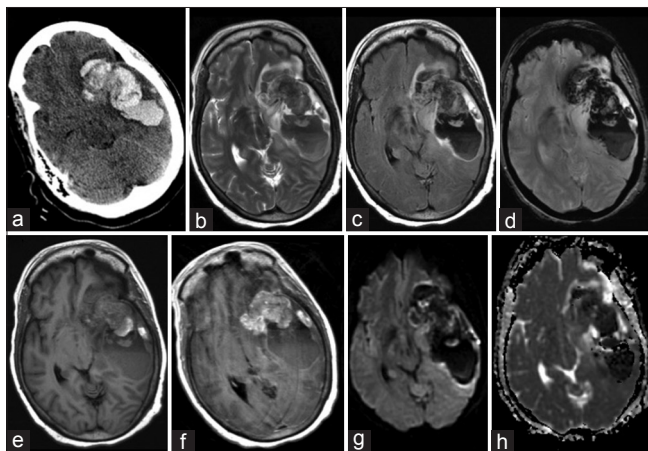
Epithelioid glioblastoma. (a) Noncontrast head CT shows a large parenchymal hemorrhage centered in the left temporal lobe and significant mass effect on surrounding brain, including left uncal herniation. Brain MRI with (b) T2 FSE, (c) T2 FLAIR, (d) GRE, (e) pre- and (f) post-contrast T1 FSE images demonstrates a lobulated enhancing hemorrhagic mass in the left anterior temporal lobe attached by a stalk to the left insula, moderate surrounding edema, and central vascular flow voids from the left middle cerebral artery. Acute hemorrhage with blood-fluid levels fills mostly a thin-walled cystic space posterior to the mass in the left temporal lobe as well as a smaller region in the left inferior frontal lobe. (g) DWI and (h) ADC map show a region of reduced diffusion medial to the mass within the left insula, probably infiltrative hypercellular tumor or acute ischemia from the mass
